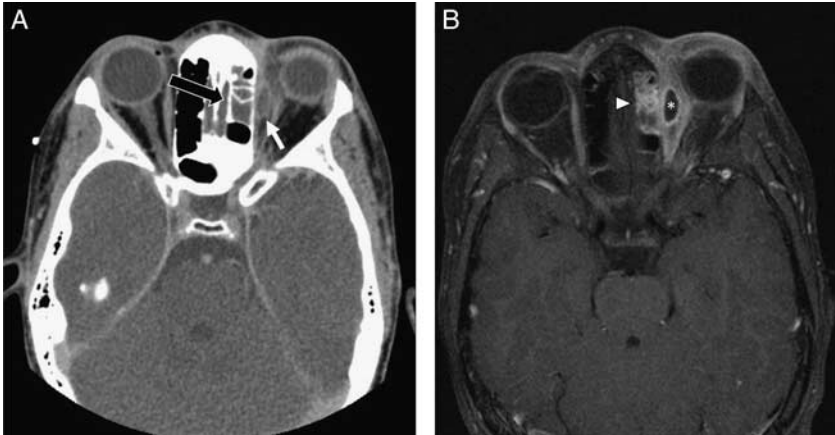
10-year-old boy presented to the emergency department with 1 week of left eye erythema and edema. Axial contrast-enhanced computed tomography (A) shows a rim-enhancing low attenuation collection along the left lamina papyracea (white arrow). There is opacification of the underlying ethmoid air cells suggestive of sinusitis (black arrow). Axial T1-weighted postcontrast fat-saturated magnetic resonance imaging (B) demonstrates the subperiosteal abscess along the left lamina papyracea (white asterisk) with underlying ethmoid sinusitis (white arrow head).
